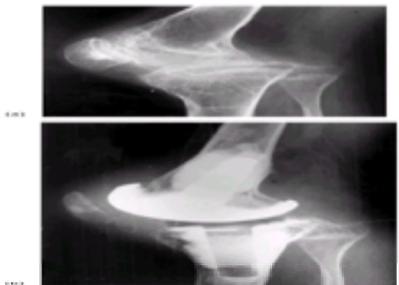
The same patient as depicted in [Fig. 5](#); after hip arthroplasty further deterioration occurred in both knees. (a) Preoperative radiograph at age 16 years: note the severe degree of osteoporosis, overgrowth of the patella, posterior subluxation of the tibia, and the marked depression of the tibial plateau. An anteroposterior view showed the knee to be in a marked valgus position as a result of the collapse of the lateral tibial plateau but also an overgrowth of the medial femoral condyle. (b) Total knee replacement using an Attenborough prosthesis. The small size, destroyed surface, and osteoporosis are best suited to an unrestrained, stemmed prosthesis with cement. Some newer designs of total condylar replacement are proving satisfactory after adolescence when the disease has become inactive. This patient has now regained mobility having lost the flexion contractures in both hips and both knees, and in each case has a flexion range of 90° or more.
